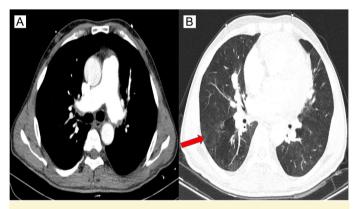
Thorax CT on admission shows dilated pulmonary arteries (A), mosaic perfusion pattern in lower lobes (B). CT, computed tomography.
